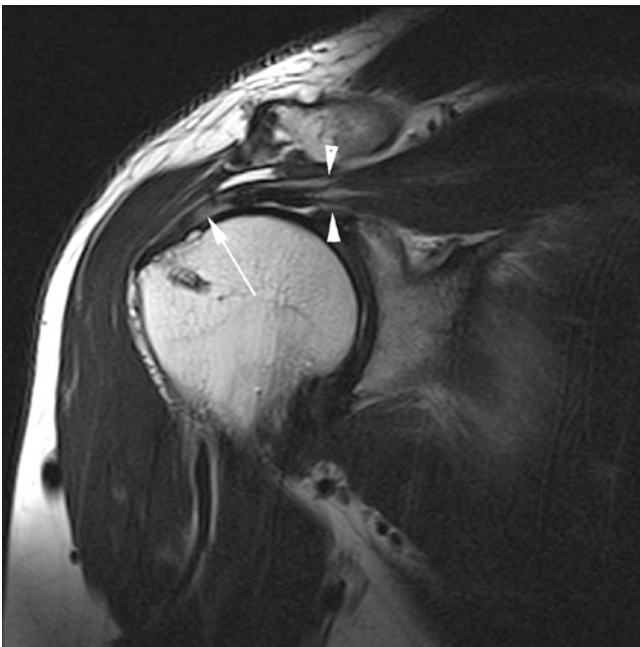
Coronal oblique T2-weighted image demonstrates intermediate signal scarring/fibrosis (arrow) filling the gap at the site of a recurrent supraspinatus tear. Another clue to the presence of a tear with retraction is the medial displacement of the myotendinous junction of the supraspinatus (arrowheads) nearly to the level of the glenoid
